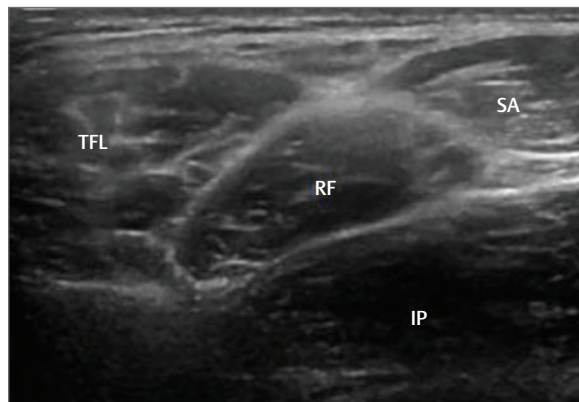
Ultrasound image of the upper third of the thigh distal to the AIIS demonstrating the muscle belly of rectus femoris (RF) situated between the muscles of tensor fasciae latae (TFL) laterally and sartorius (SA) medially. The muscle belly of iliopsoas (IP) can be seen deep to the rectus femoris.
